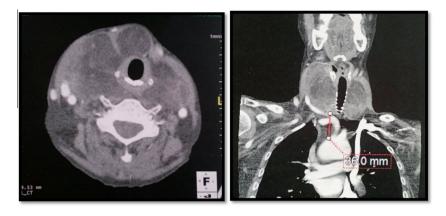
Contrast-enhanced CT in axial and coronal view showing a diffuse goiter with adipose density.
